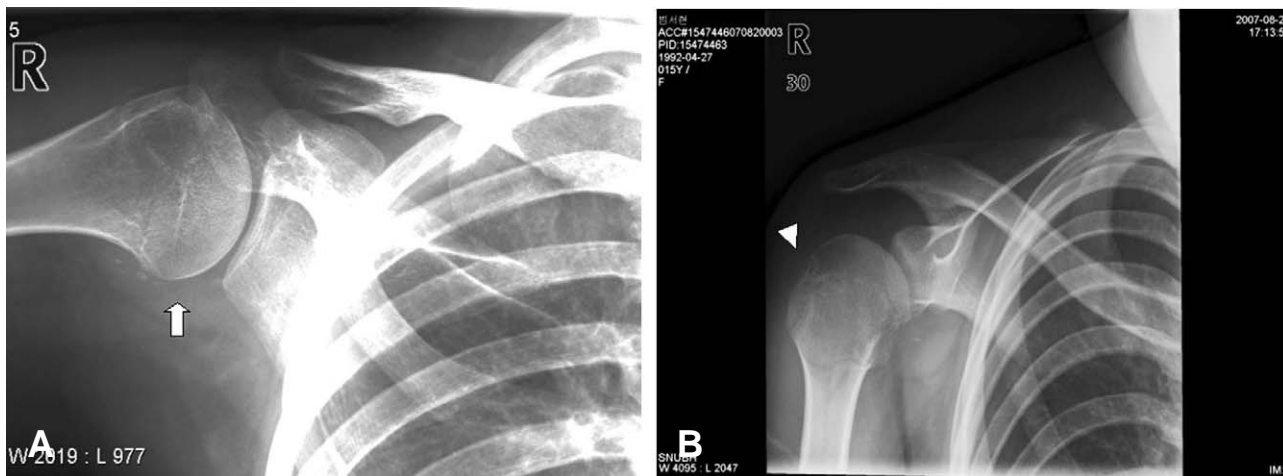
(A) Anteroposterior radiograph of the right shoulder demonstrates the presence of multiple calcifications in the shoulder joint, mainly inferiorly (arrow). (B) Apical view shows erosion at posterolateral aspect of the right humeral head (arrow head).
